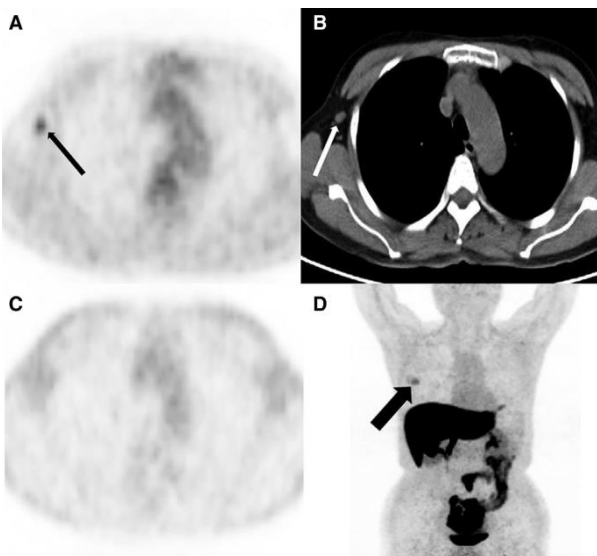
A 49-year-old woman with newly diagnosed estrogen receptor-positive breast cancer. (A): Axial ^{18}F -FDG positron emission tomography (PET) shows right axillary focal uptake (black thin arrow). (B): Axial computed tomography (CT) shows the right axillary lymph node on one level (white thin arrow). (C): At the same level, there is no focal uptake in the ^{18}F -FES PET. (D): ^{18}F -FES PET MIP showed breast mass uptake (black thick arrow) but no focal uptake in right axillary lymph node. The right axillary lymph node was not a metastasis as proven by pathology after operation.
